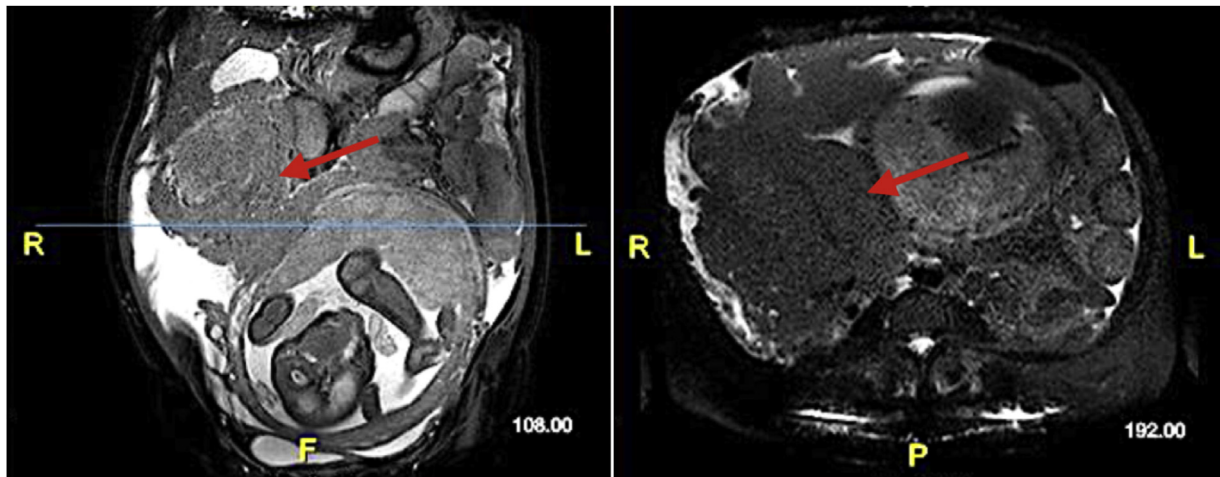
Abdominal MRI (coronal and axial) sections. Note the displacement on the left of the uterus due to the “mass effect” of the tumor.
